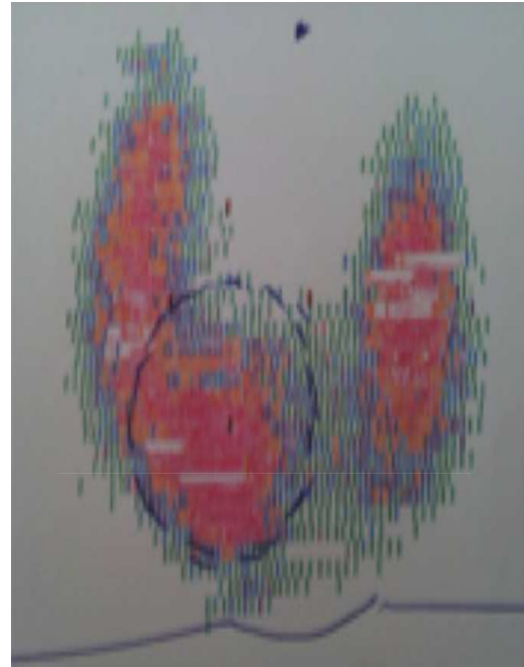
Thyroid scintigraphy showing a high uptake of the radioiodine by the thyroid nodule.
